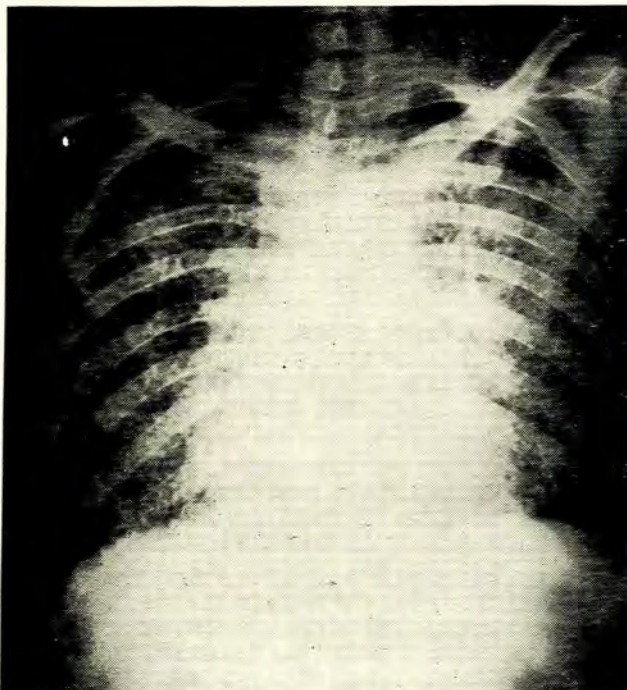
X-ray of the chest showing bronchopneumonic changes.
